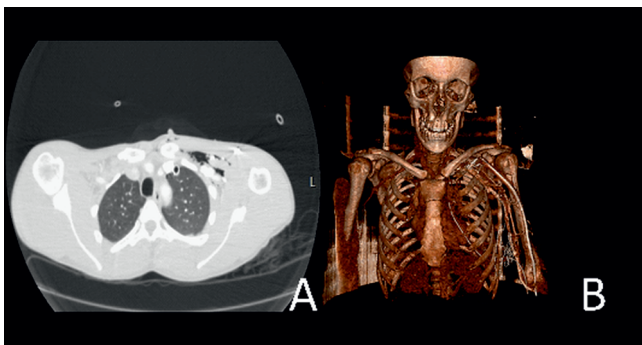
Thorax CT (A) and 3D (B) images show left thorax drain, subcutaneous emphysema on the left side of the neck and fractures of the ribs at the anterior chest wall
